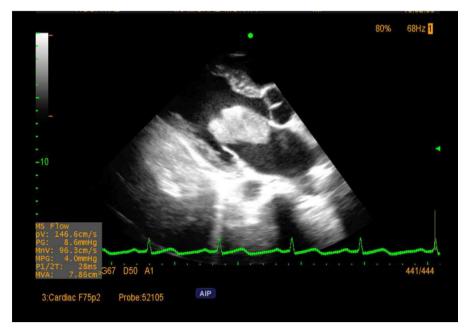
Transthoracic echocardiogram: parasternal long-axis view of the heart revealed a 5.4 x 2.5 cm highly mobile mass in the left atrium attached to interatrial septum.
